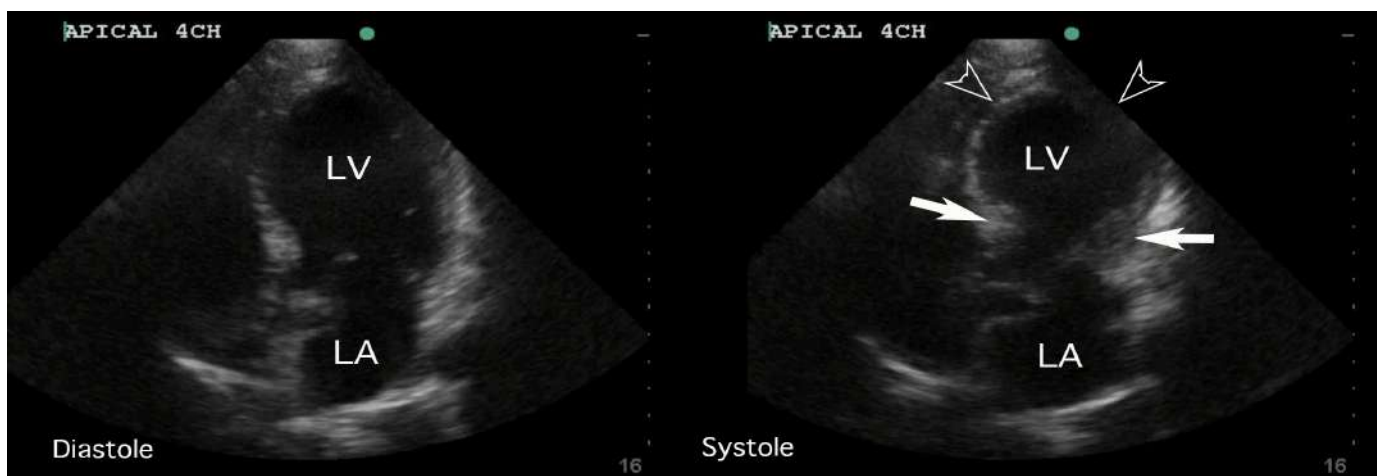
This apical 4-chamber view of the heart performed by the emergency physician demonstrates findings of apical ballooning, with systolic mid to apical hypokinesis of the left ventricle (LV). The basal segments near the atrioventricular septum contract appropriately in systole (solid arrows), but the mid to apical segments of the left ventricle show minimal contraction and demonstrate ballooning when systole is compared to diastole (outlined arrowheads). These findings match the description of the classic apical variant of takotsubo cardiomyopathy, which is said to resemble an octopus pot. LA, left atrium.
